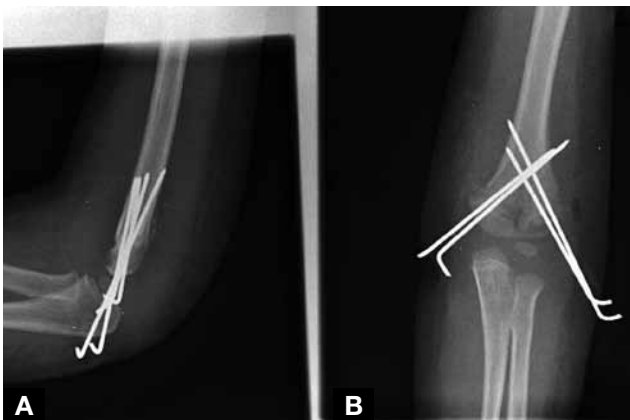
Final intraoperative (A) lateral and (B) anteroposterior radiographs show fixation of both the medial and lateral condyle fragments.
